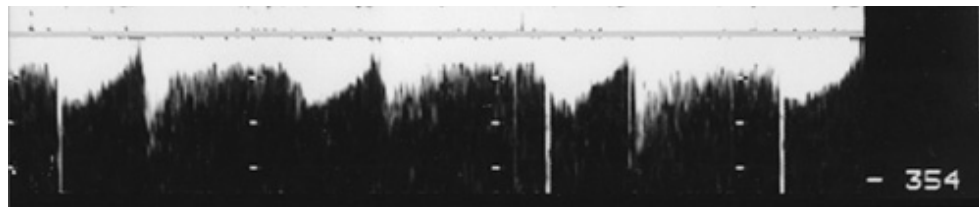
Pulsed-wave (PW) and continuous-wave (CW) Doppler. With PW, a single pulse of ultrasound energy is emitted and its reflection from a sample volume is received before the following pulse is transmitted. With CW, there is continuous transmission and reception of ultrasound energy.
